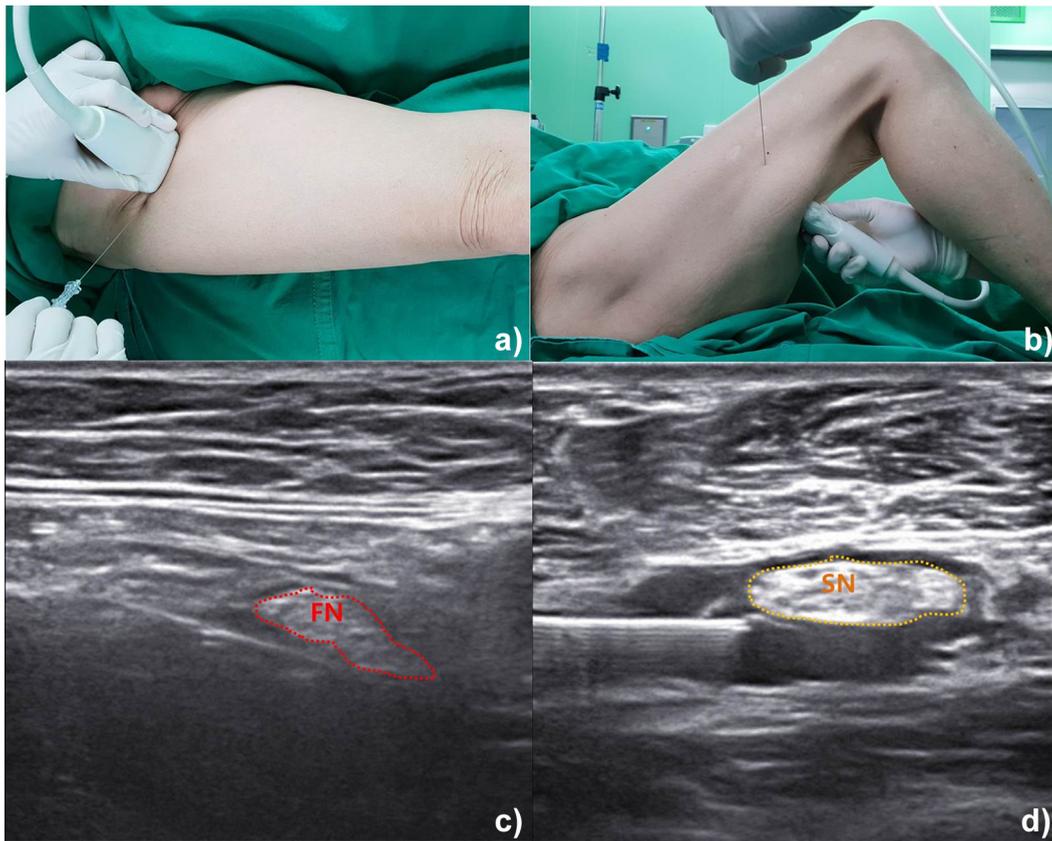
Nerve block: Patient positions and ultrasound images. Nerve block: Patient positions and ultrasound images. a) Femoral nerve block with the patient in the supine position at full hip and knee extension. b) Sciatic nerve block with the patient in the supine position at 90° knee flexion and 45° hip flexion. c) Ultrasonographic image after femoral nerve (FN) block. d) Ultrasonographic image after sciatic nerve (SN) block.
